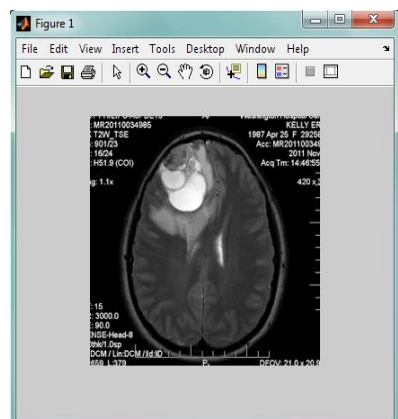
Input MRI Image
